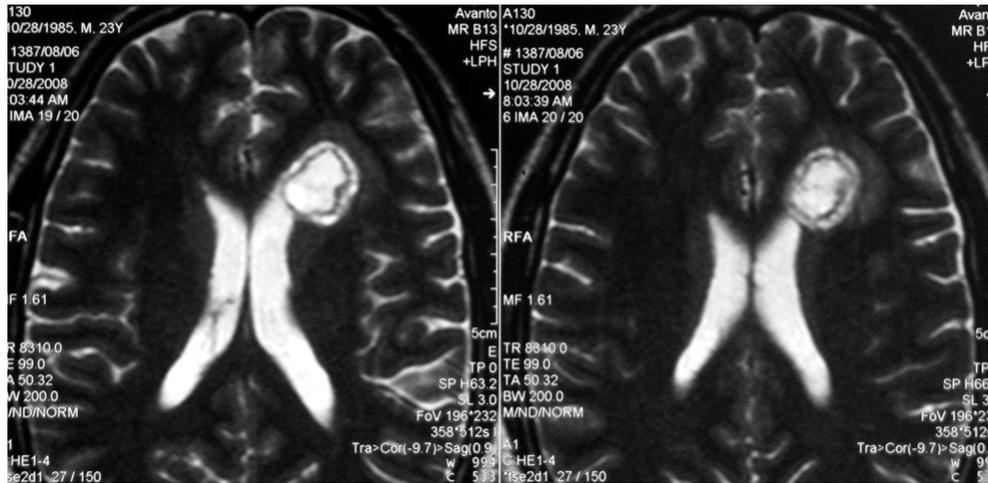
Magnetic resonance imaging examination showed a thick wall cystic lesion with a mural nodule in close proximity of the anterior horn of the left lateral ventricle
